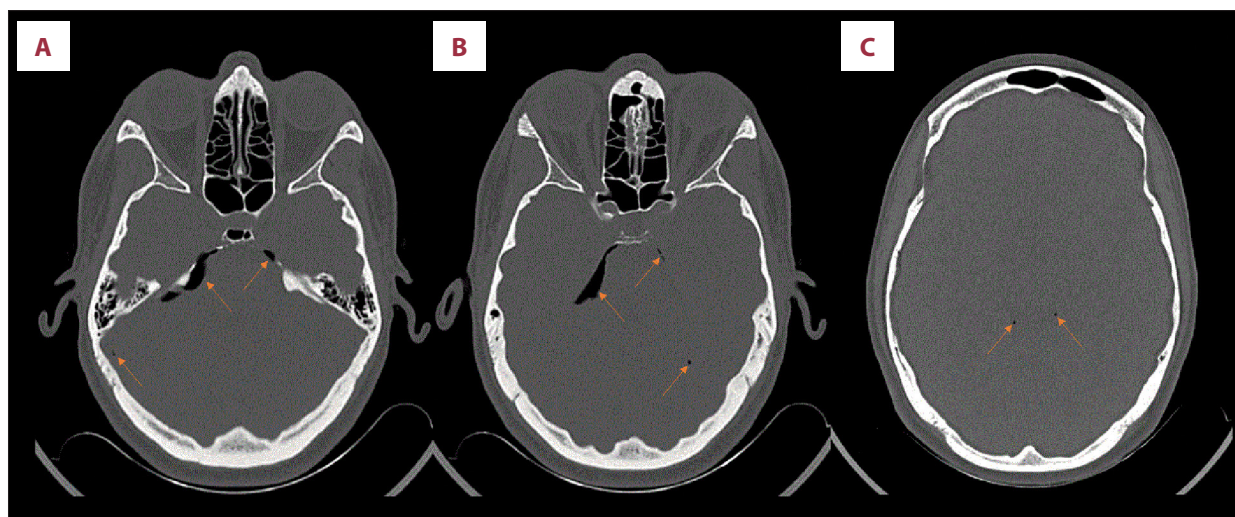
(A-C) Axial unenhanced CT on bone window showing pneumocephalus (arrows).
